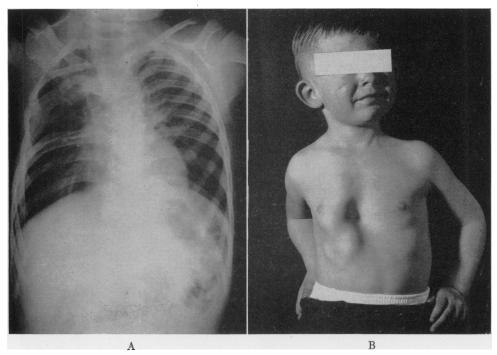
A. Roentgenogram of the chest of a child with short and defective upper ribs on the right. The ribs below are normal. B. Photograph of the same child showing protrusion deformity of the normal ribs.
